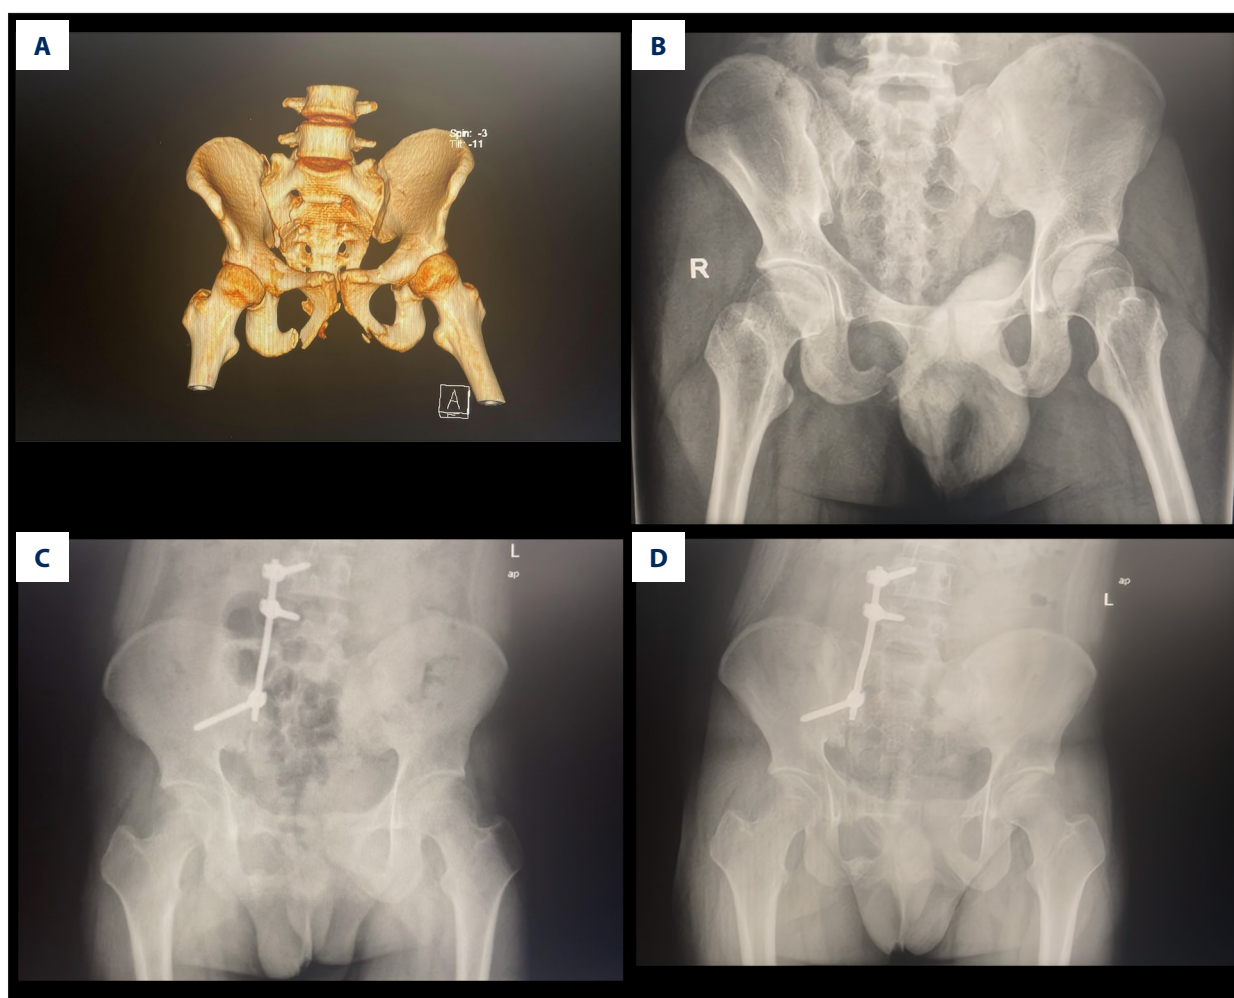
Posterior lumbar combined screw internal fixation for a male patient with Tile C-type pelvic fractures. (A) Preoperative 3-dimensional reconstruction of pelvis. (B) Preoperative pelvic anteroposterior X-ray. (C) Postoperative pelvic anteroposterior X-ray 3 month after surgery. (D) Postoperative pelvic anteroposterior X-ray 6 months after surgery. *Figure created by WPS picture (windows12.1.0.19302, Kingsoft Office).*
